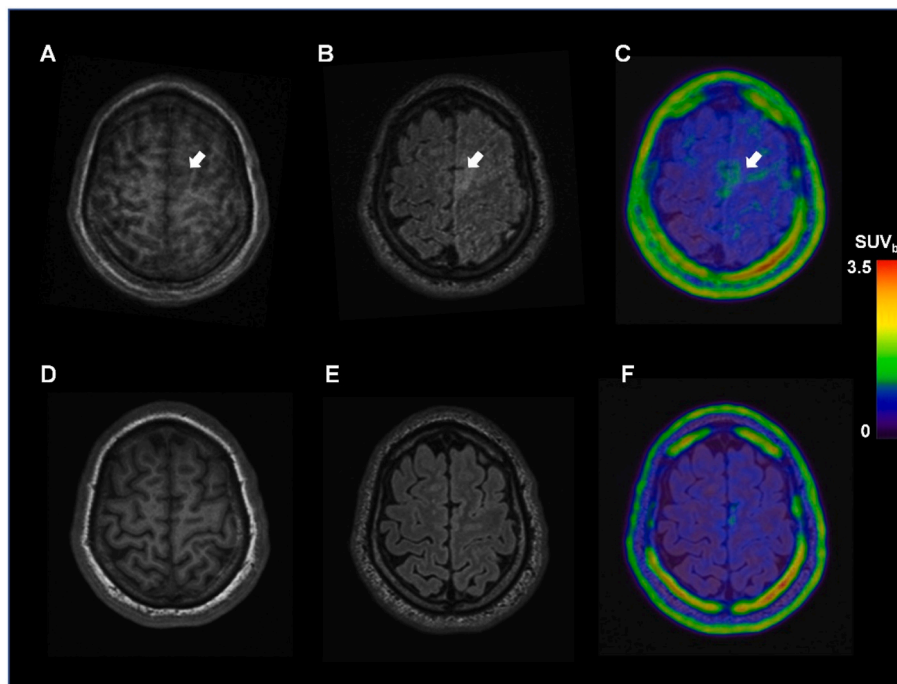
Pre-treatment A) axial T1W, B) T2 FLAIR and C) hybrid ^{18}F -DPA-714 PET/T2 FLAIR images indicated an inflammatory lesion (white arrow) in the left frontal lobe. The disappearance of the lesion with a reduction of ^{18}F -DPA-714 uptake was observed on post-treatment D) axial T1W, E) T2 FLAIR MRI and F) hybrid ^{18}F -DPA-714 PET/T2 FLAIR images.
